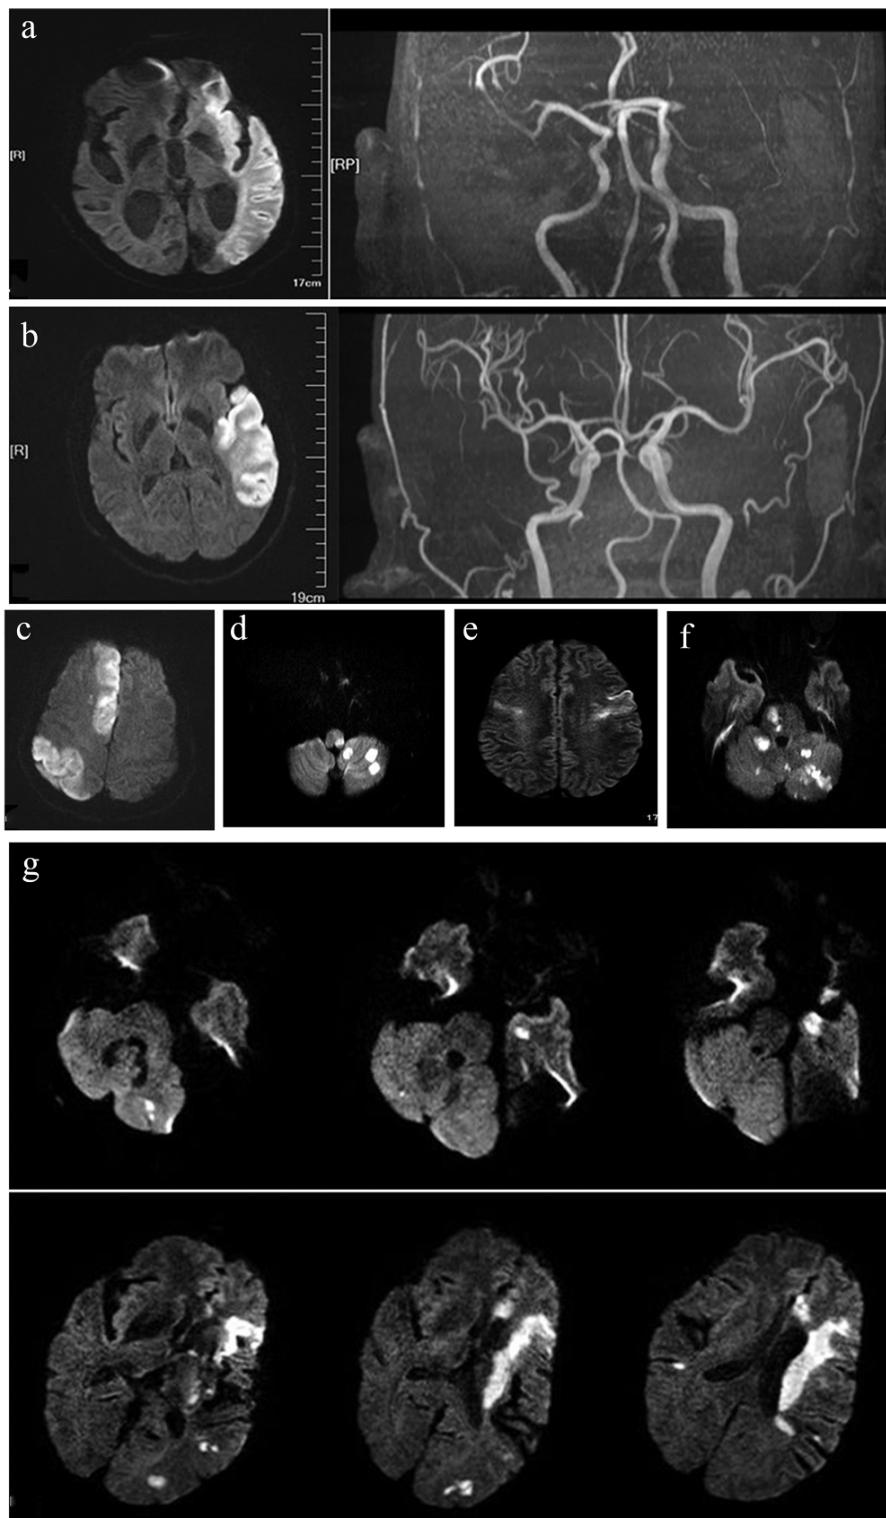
Typical types of cerebral infarction as shown by cranial MRI
